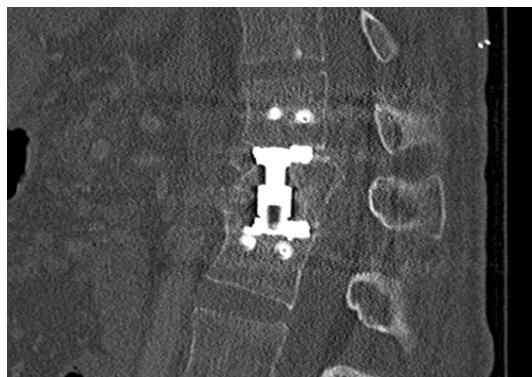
CT scan after implantation of a VBR and instrumentation with an angle-stable plate
